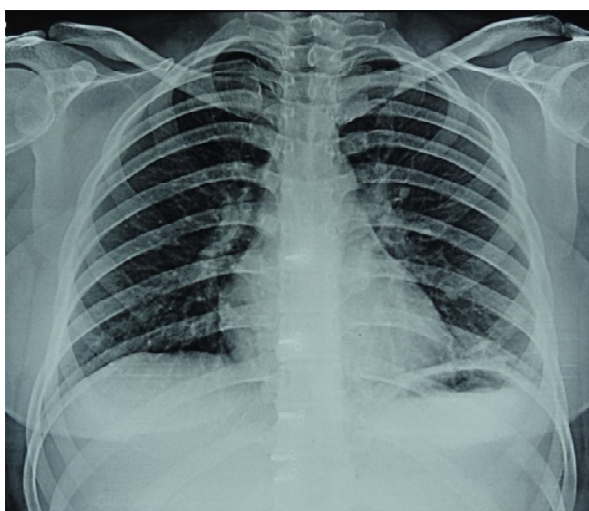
Chest radiograph (postero-anterior view) on the day of discharge showing normal findings
